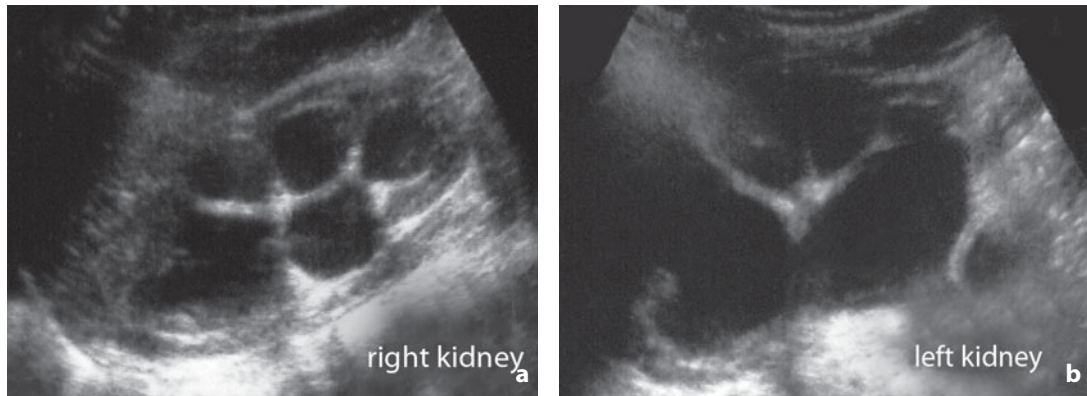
Hydronephrosis. Longitudinal sonogram shows bilateral hydronephrosis with grade IV right (a) and grade V left (b)
